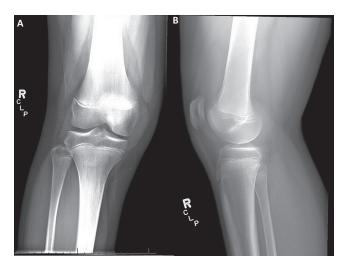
(a,b) – AP (a) and lateral (b) radiographs of the right knee. Overall alignment is anatomic, with the presence of a knee effusion. No osseus pathology observed.
